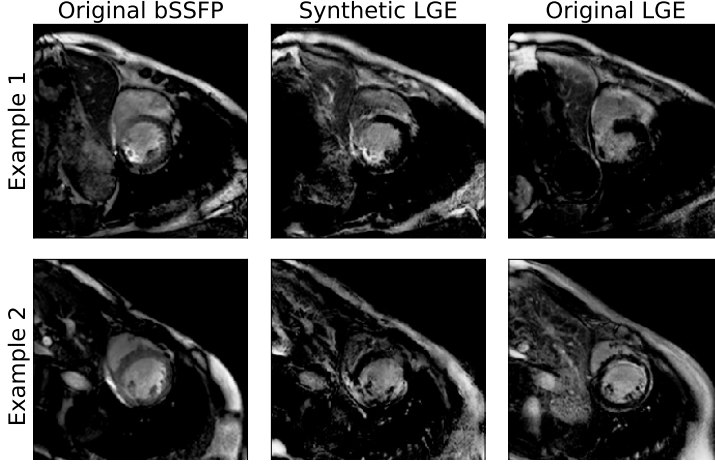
Examples of synthetic LGE-MRI images. The leftmost column are the original cine images, the central column shows the transformed images to the LGE domain and the rightmost column is the most similar slice from the real LGE sequences, since they were not registered/aligned.
